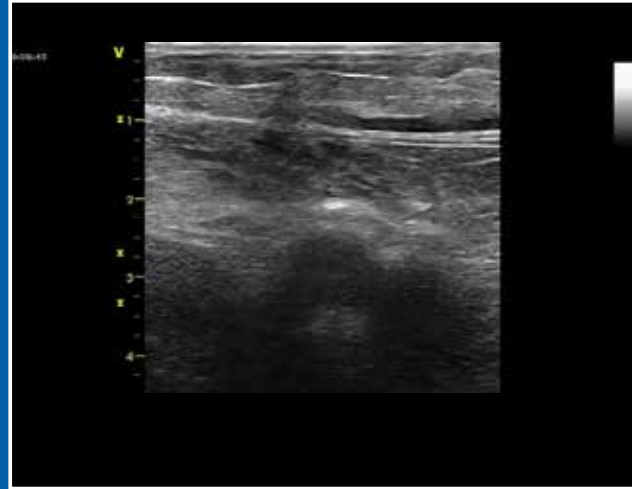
Anterior Wall Puncture Location Verified by Real-time Ultrasonography (video)
